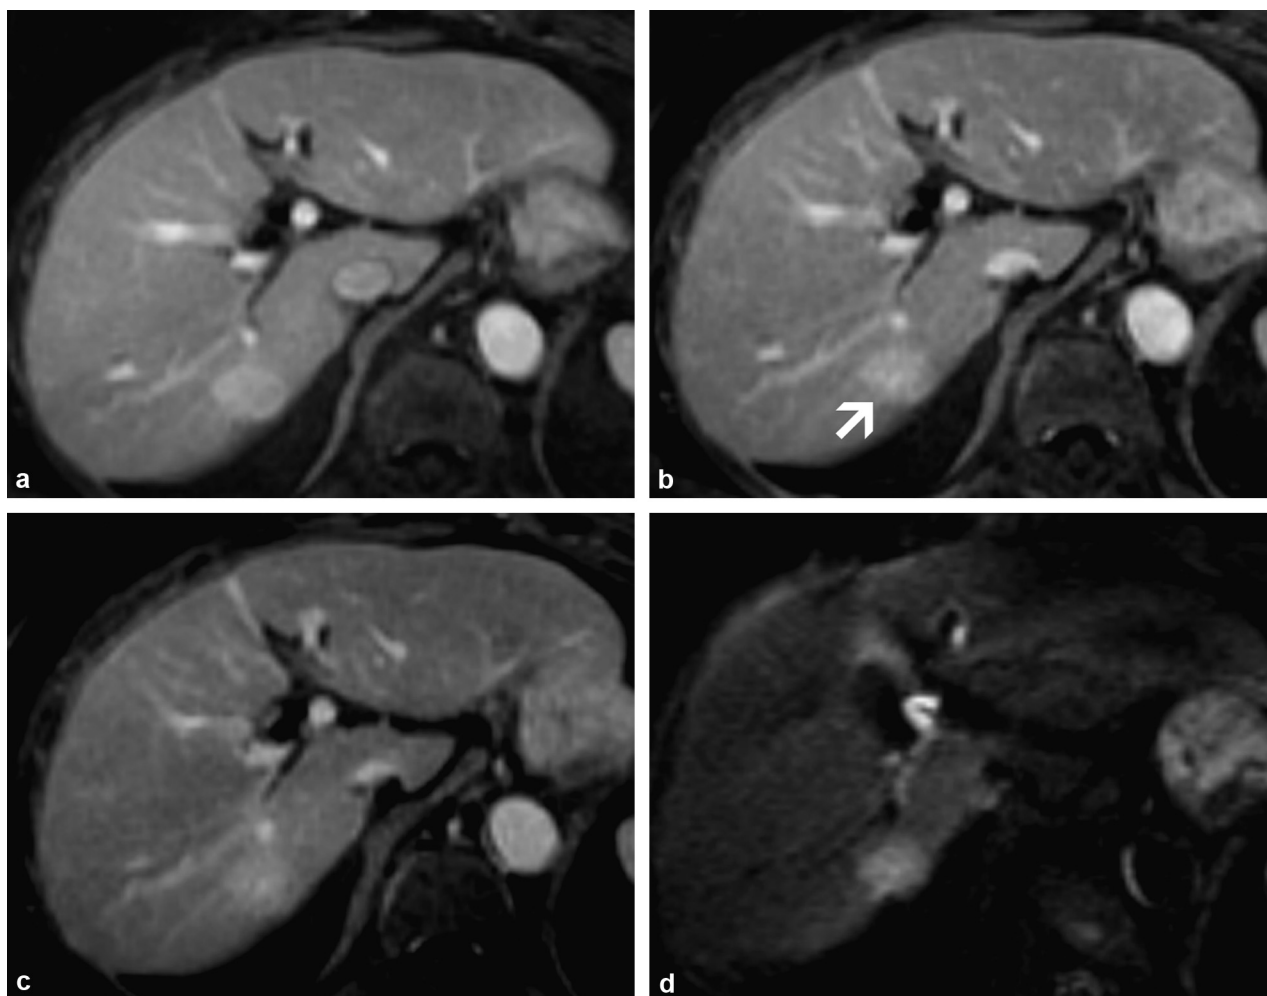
Focal nodular hyperplasia (FNH). Monitoring examination for cirrhosis of viral origin. T1-weighted MRI with fat saturation after gadolinium injection in the arterial (a), portal (b), late (c) phases and with diffusion-weighting (d): focal nodular hyperplasia (arrow), enhanced in the arterial phase with persistence of the enhancement in the portal and late phases. A small central area enhanced in the late phase is visible helping to suggest a diagnosis of FNH. Note the misleading hyperintensity of the lesion with diffusion-weighting.
